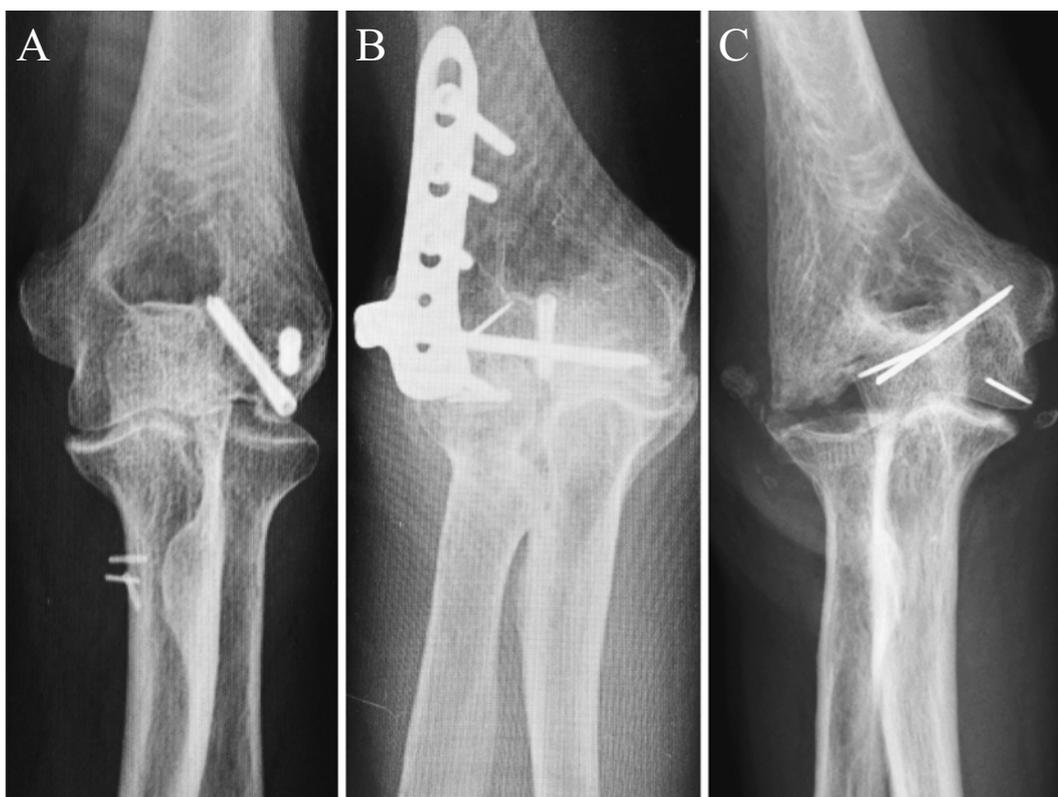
Representative anteroposterior radiographs of three patients at the final follow-up examination. A: anteroposterior radiograph of a 75-year-old woman (Case 3, 49 months postoperatively) showing a step-off deformity (>2 mm) of the articular surface, slight joint-space narrowing, and minimal osteophyte formation (Broberg and Morrey, Grade 1). B: anteroposterior radiograph of a 79-year-old woman (Case 8, 24 months postoperatively) showing collapse of the entire articular surface of the trochlea and capitellum, and moderate joint-space narrowing with osteophyte formation (Broberg and Morrey, Grade 2). C: anteroposterior radiograph of a 74-year-old woman (Case 7, 18 months postoperatively) showing an articular fragment of the trochlea and capitellum that had failed to heal and were to be resorbed, indicating avascular osteonecrosis, and severe joint space narrowing with gross destruction (Broberg and Morrey, Grade 3).
